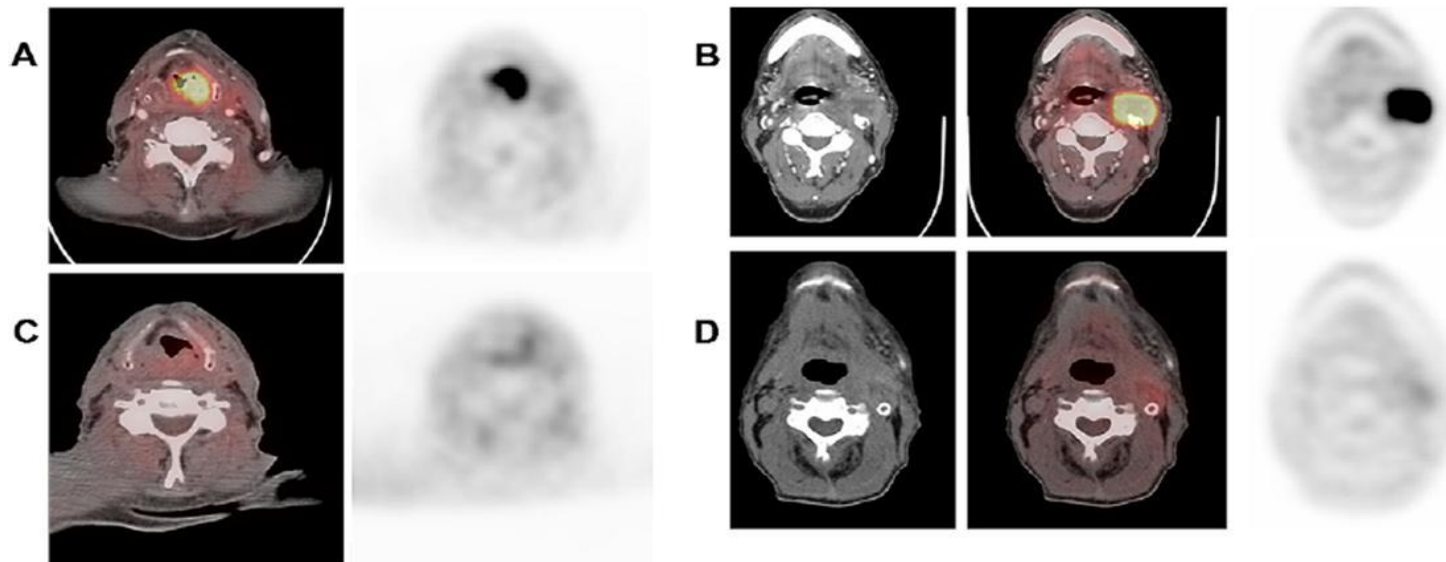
Positron emission tomography–computed tomography (PET-CT) scans of recurrent squamous cell carcinoma of the head and neck: primary (A, C) and cervical (B, D) metastatic disease before (A, B) and after (C, D) stereotactic body radiotherapy.
